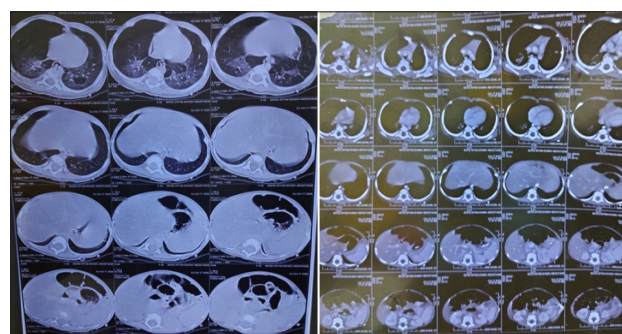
a.HRCT Chest at 3½ Months of Age showing right and left upper lobe ground glass opacities; b.CECT Chest at 15 Months of Age
